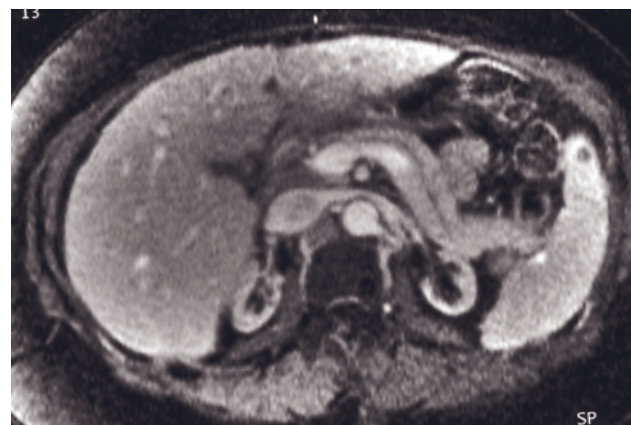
End-stage kidneys secondary to sustained hypertension. Coronal T2-weighted SS-ETSE (a), transverse T1-weighted precontrast (b), and immediate (c) and 2-min fat-suppressed (d) postgadolinium SGE images. Bilateral diminutive atrophic
